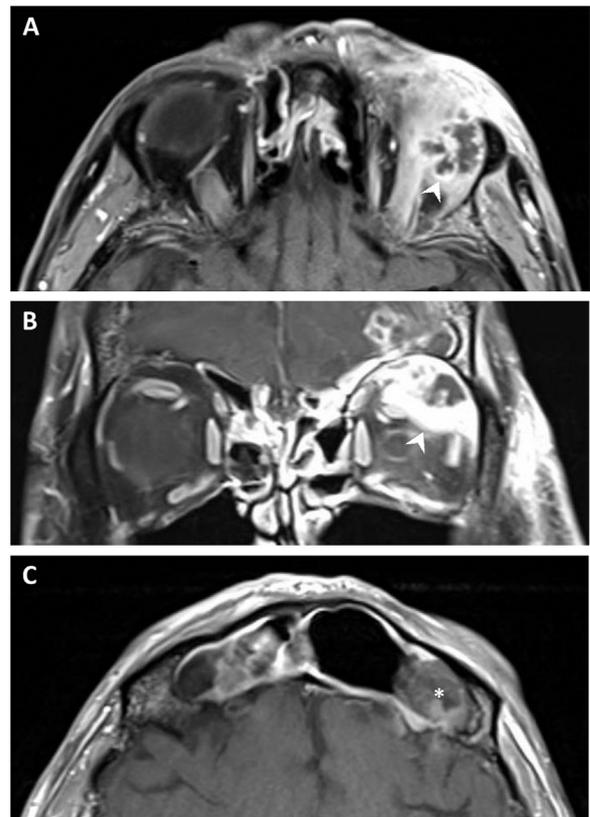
Magnetic resonance imaging. (A) Axial image showing a left-sided enhancing lateral orbital lesion (arrowhead) with central hypointensity correlating with an area of abscess. (B) Coronal image showing superolateral mass with peripheral enhancement (arrowhead). (C) Axial view of the left frontal sinus with mucosal enhancement and a hypointense mass (*).
